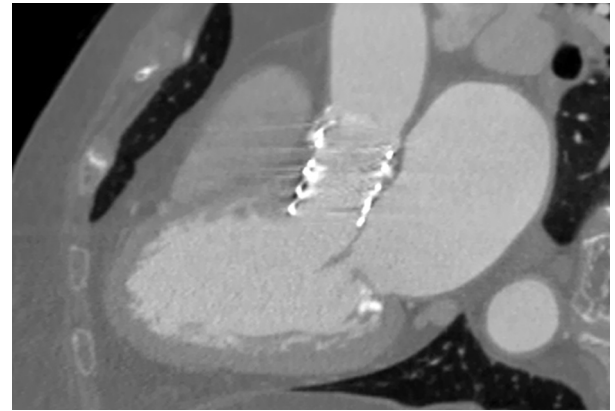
Cine CT Scan at Follow-Up
